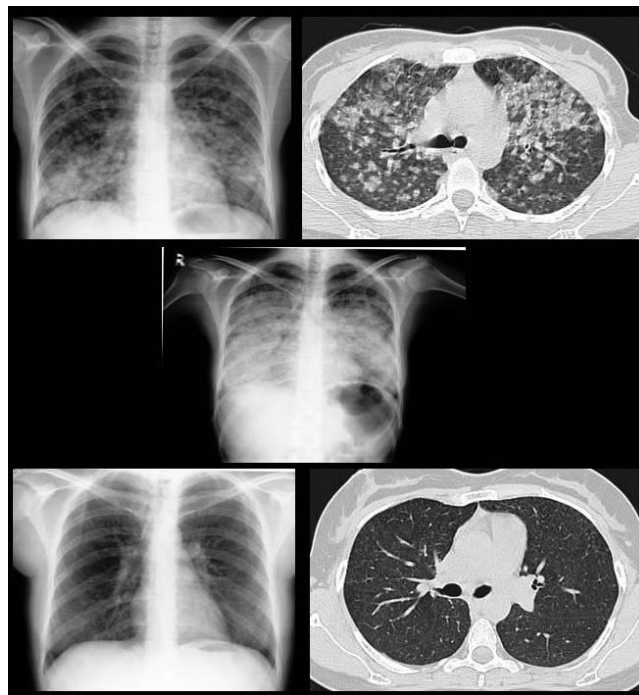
Chest x-ray and computer tomography of patient
